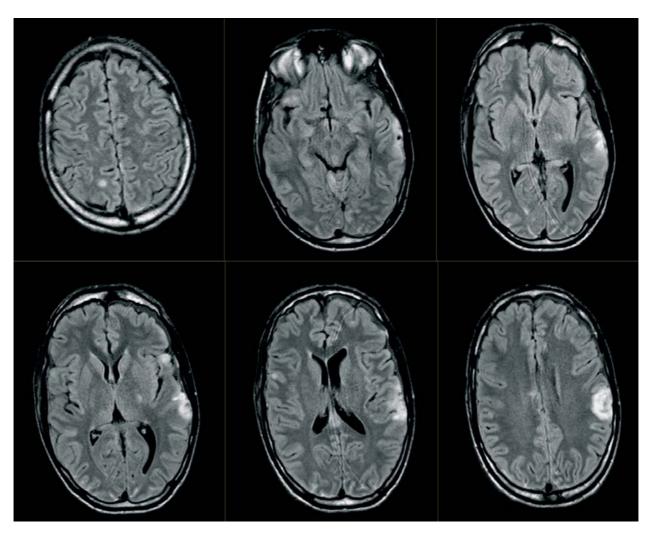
T2 axial brain MRI performed four days after admission, which revealed several contusive injuries, a subtle left subdural hematoma in temporal and frontal regions and posttraumatic subarachnoid hemorrhage.
